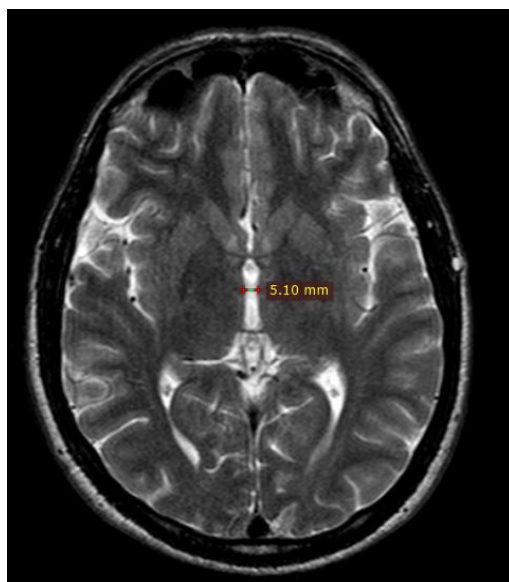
MRI of the brain at the level of the third ventricle in a male showing the measurement of the third ventricle width in mm. The red line indicates the TVW.
